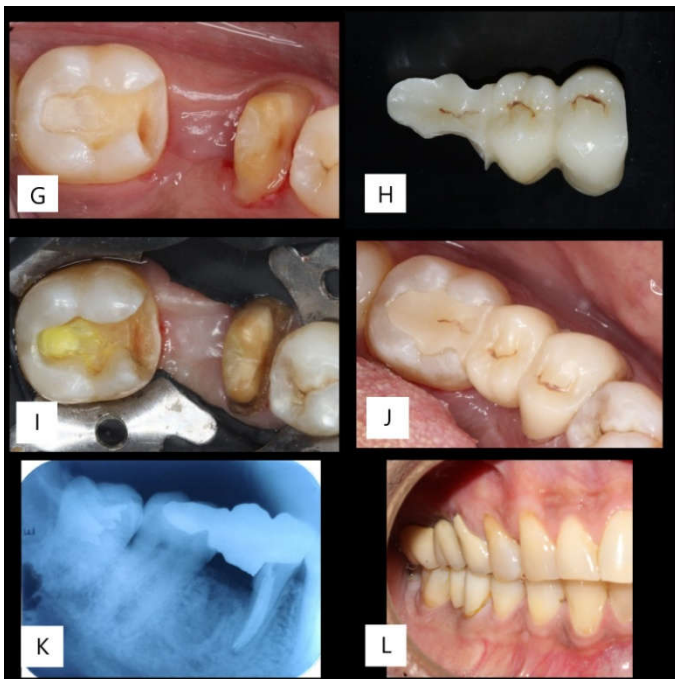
G – Tooth preparation, H – Hybrid-retained prosthesis, I – Isolation with split dam technique, J – Post-cementation, K – 6 months follow-up radiograph, L – Follow-up lateral view
